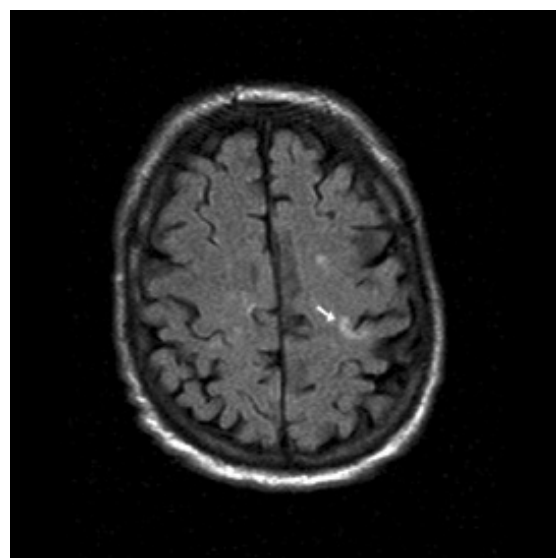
MRI FLAIR sequence showing an area of hyperintensity in the hand knob area of the left hemisphere.
